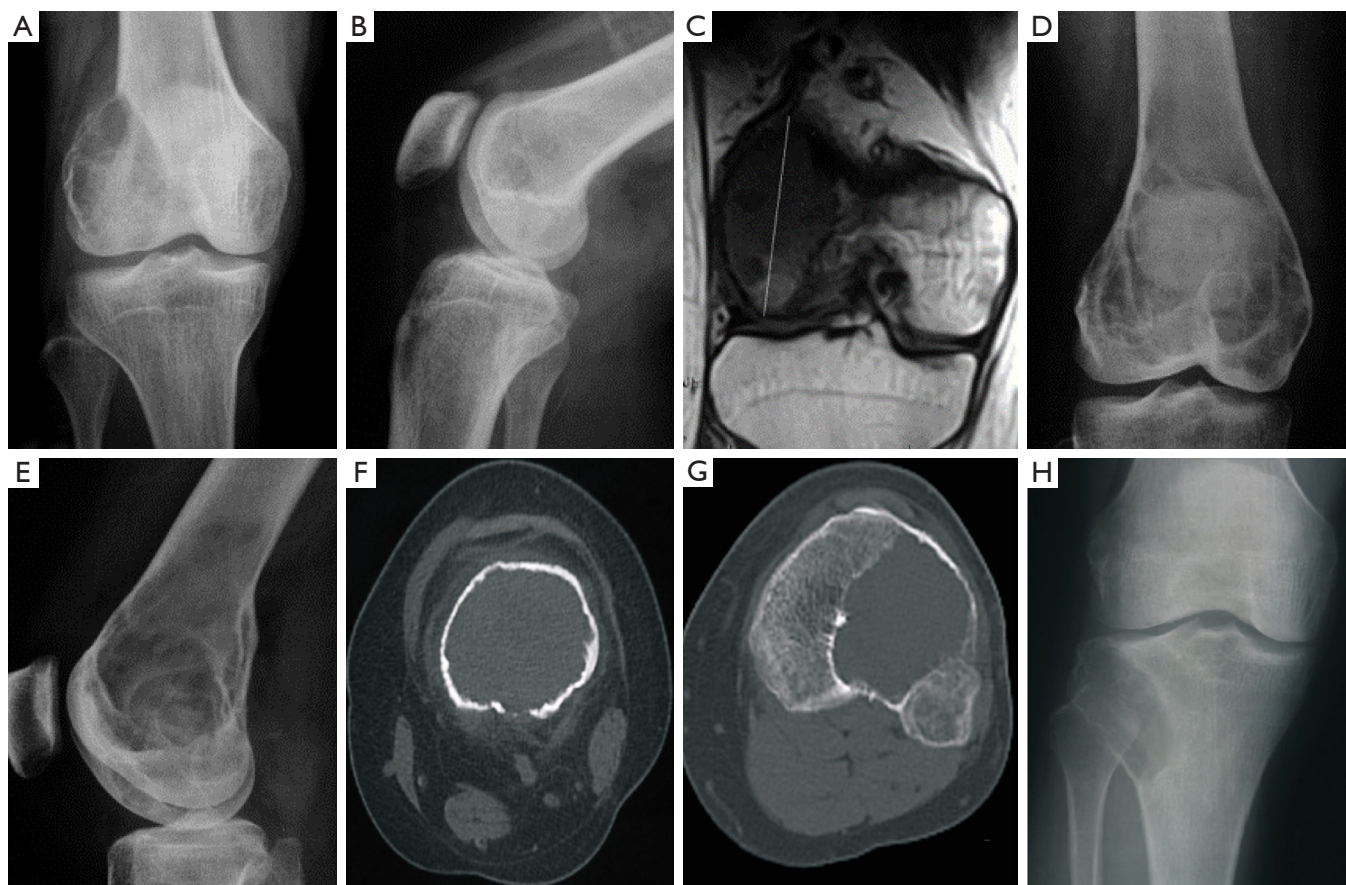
Giant cell tumors of the bone. (A-E) Images are from 1 patient. (A,B) Plain radiography showed an eccentric, expansile, lytic lesion on the lateral condyle of the right femur with a narrow zone of transition, extending down to the joint surface with a thin bony cortex and fine ridges. (C) Magnetic resonance imaging T1-weighted image on the coronal plane demonstrated the lesion to have a nonuniform long T1 signal with a limited range of disease and a clear boundary. (D,E) Plain radiography revealed a big, expansile, lytic lesion in the distal end of the right femur, extending downward to the joint surface and upward to the bone diaphysis with coarse bone ridges inside. (F-H) Images from another patient. (F) CT showed expansile destruction in the distal end of the left tibia with uniform density and disrupted cortical bone but no apparent sclerotic margins. No soft tissue mass was present. (G) CT revealed an expansile eccentric destruction at the proximal end of the left tibia bone with uniform intratumor density, a partial sclerotic margin, and no soft tissue mass. (H) Plain radiography demonstrated expansile eccentric destruction at the lateral condyle of the right tibia with uniform intratumor density and a partial sclerotic margin. CT, computed tomography.
